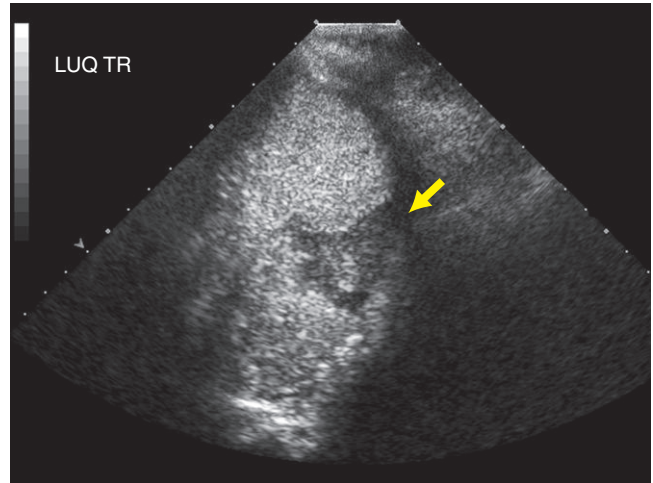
Using ultrasound contrast another repeat ultrasound of the spleen was performed demonstrating normal echogenicity of the spleen, with a non-perfused, hypoechoic region (arrow) corresponding to splenic laceration.
